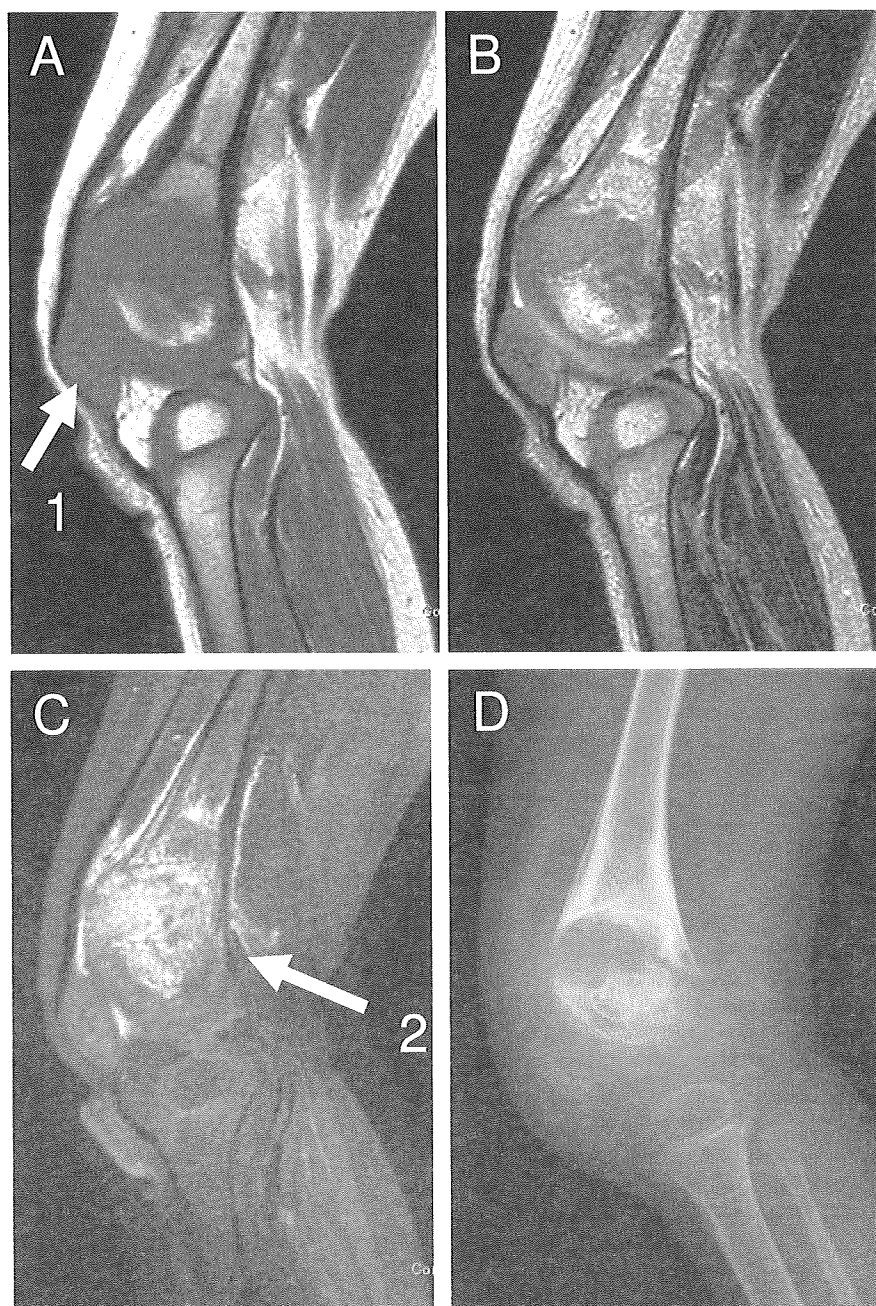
Sagittal MR images and lateral radiograph of the left knee at 2 years and 7 months of age, prior to introduction of anakinra. . (A: MRI T1-weighted, B: MRI T2-weighted, C MRI T1-weighted with fat suppression and gadolinium-enhancement, D radiograph): T1- and T2-weighted MR images show widening of the growth plate (arrow 1), and a gadolinium-enhanced MR image shows mottled enhancement at the chondroosseous junction (arrow 2).
